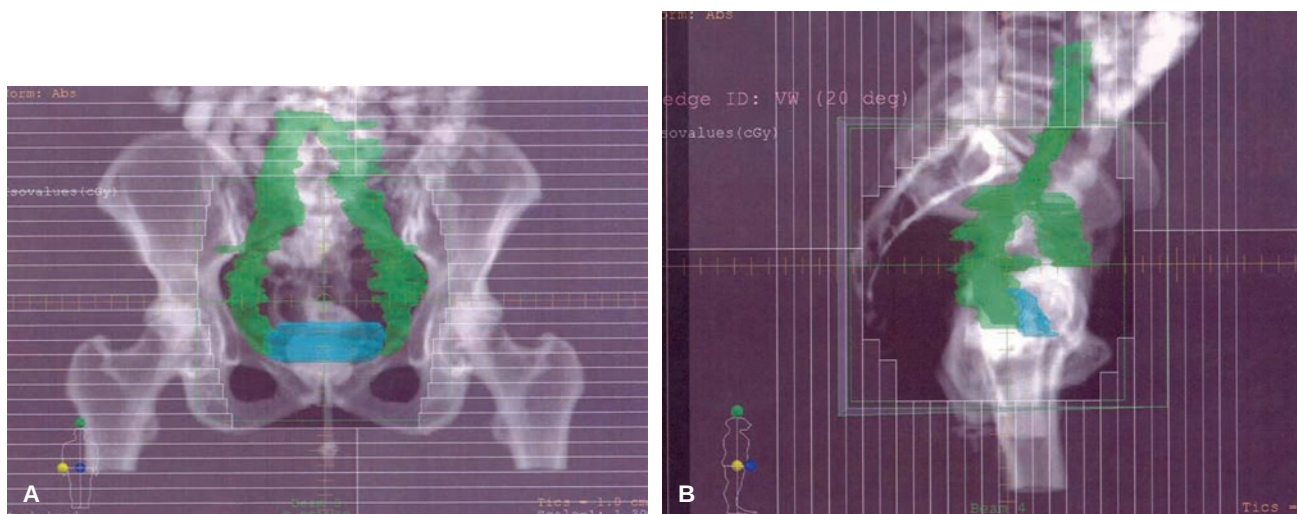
Digitally reconstructed AP A: and lateral B: radiographs with nodal volumes contoured as well as the vaginal apex and the fields defined by the leaves of multileaf collimator. This is a standard field design for patients with endometrial cancer.
